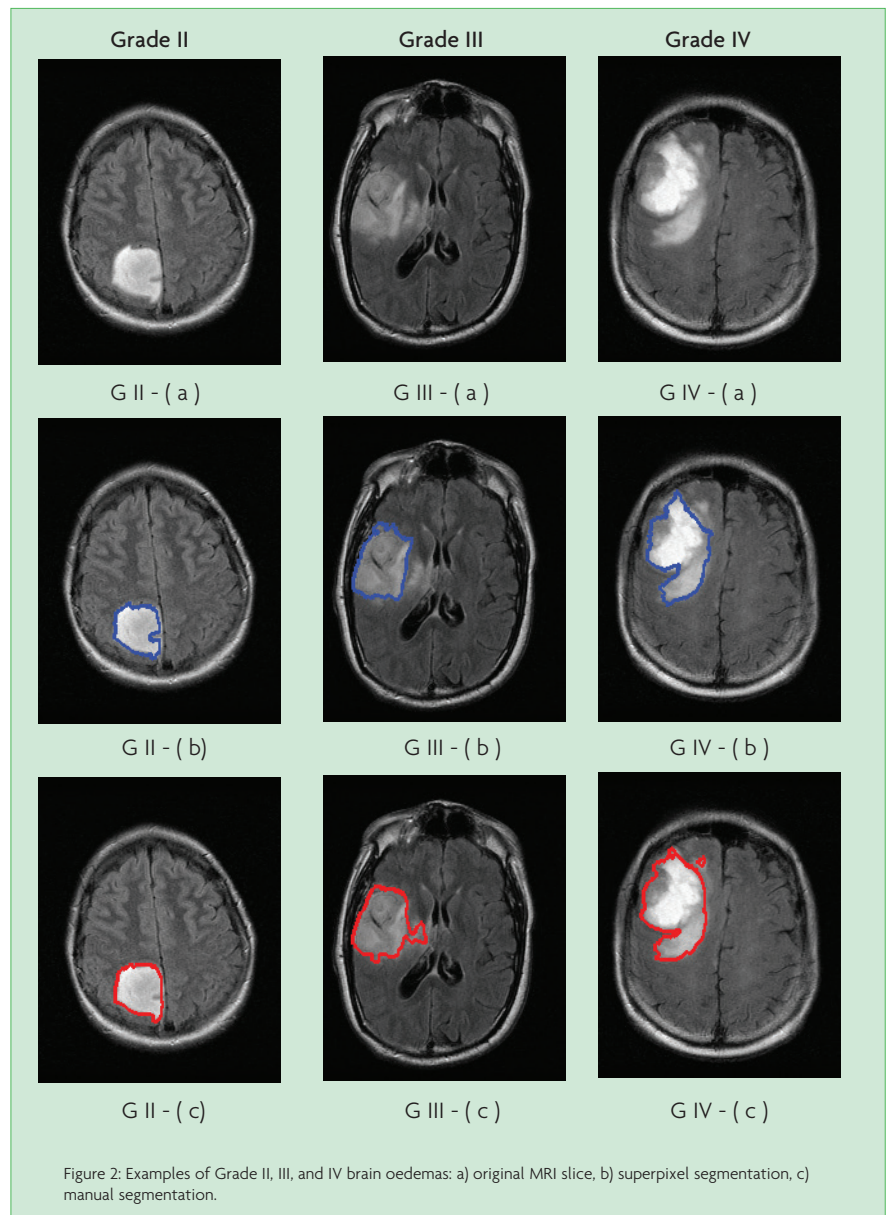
Examples of Grade II, III, and IV brain oedemas: a) original MRI slice, b) superpixel segmentation, c) manual segmentation.
